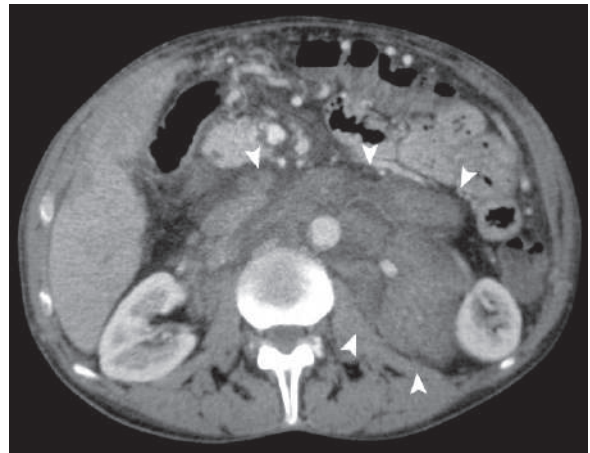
Axial abdominal portal phase, contrast-enhanced CT shows diffuse lymphadenopathy in the retroperitoneum around the aorta and the inferior vena cava (arrowheads) in a patient with Castleman's disease
